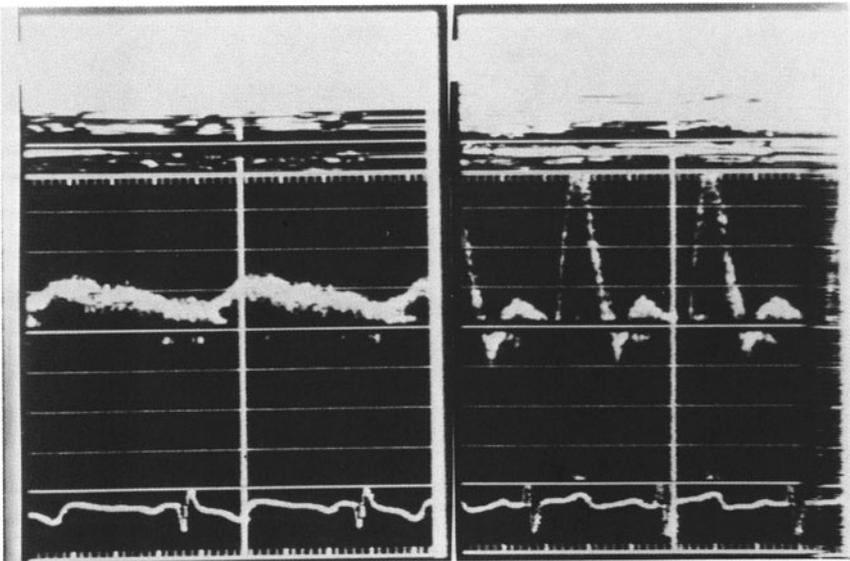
(Left) Before balloon dilatation angioplasty. Pulsed Doppler spectral waveform in the descending aorta shows slow upslope and downslope and markedly diminished peak flow velocity. (Right) Following angioplasty, a normalization of descending aortic pulsed Doppler spectral waveform.
